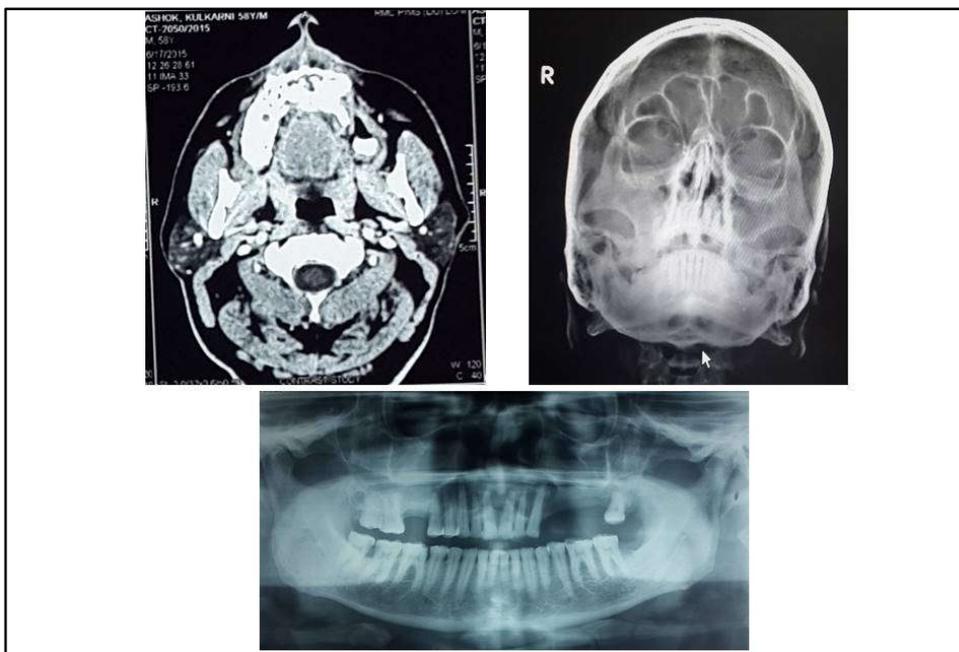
Preoperative radiograph showing a radiolucent lesion with ill-defined orders in relation to upper jaw, resorption of left maxillary alveolus and maxillary sinus invasion
